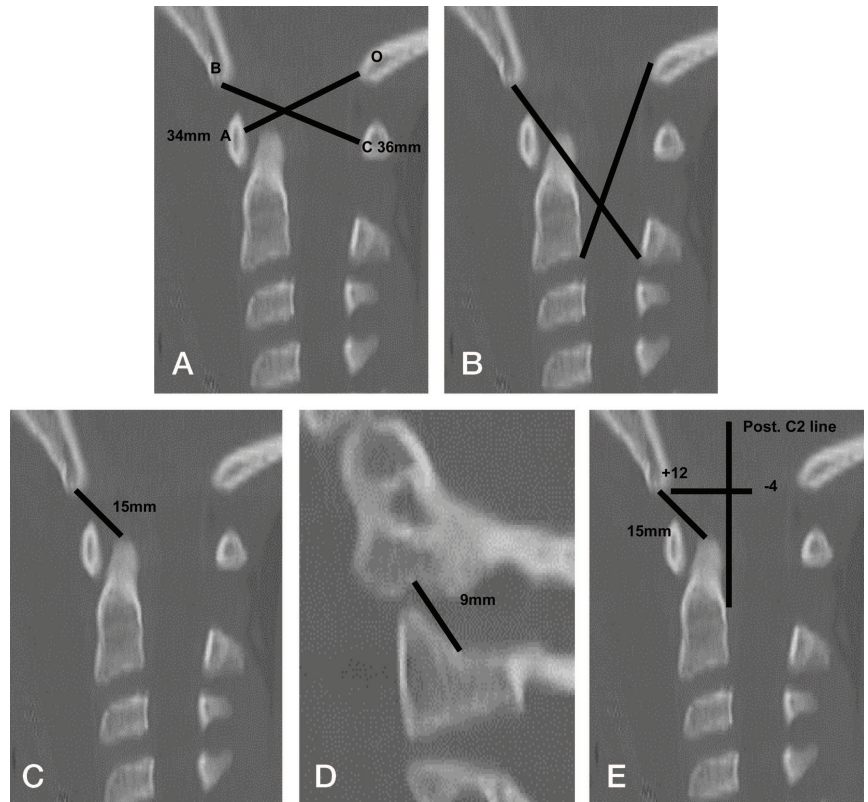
AOD shown on the CT scans of a pediatric patient. A, Power's ratio-line segments BC/OA, 36/34 mm = 1.1. B, X-line method. Posterior-superior aspect of dens and spinolaminar line at C1 are not intersected. C, Basion-dens interval, 15 mm. D, Condylar gap is 9 mm, 4 mm higher than the maximum 5 mm allowed in pediatric patients. It is anteriorly displaced. E, Harris method. Basion-dens interval of 15 mm, higher than 12 mm allowed for this method and anteriorly displaced.
